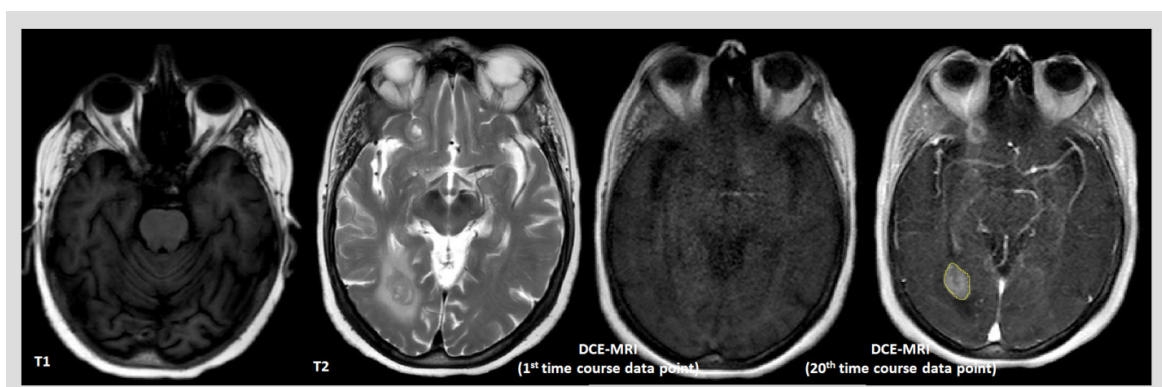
Representative MRI images of a patient with a brain metastasis: Axial T1w, T2w, DCE-MRI images during 1st and 20th time course data points.
